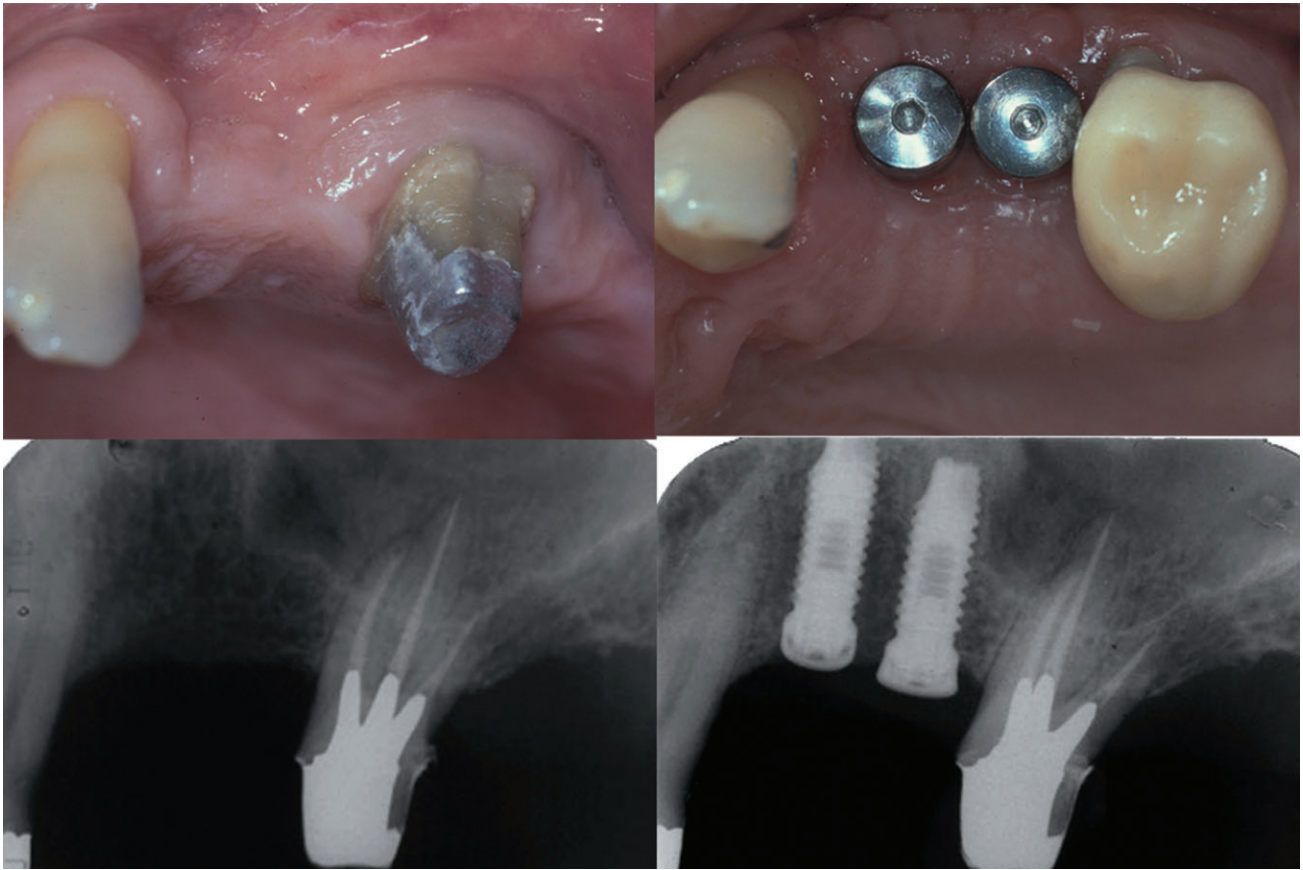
Lateral view of the edentulous ridge before and after placement of two regular implants. Note the space problem between the distal implant and the mesially inclined molar. The postoperative radiograph shows the lack of space and the closed sinus lift procedure.
